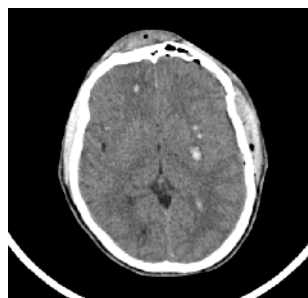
CT brain showing multiple small intracerebral haemorrhages.
